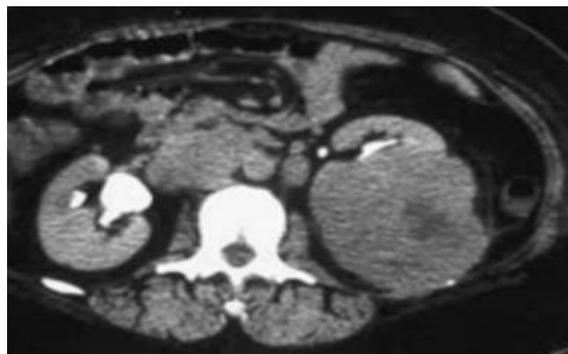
RCC seen in left kidney (contrast enhanced) CT image.
